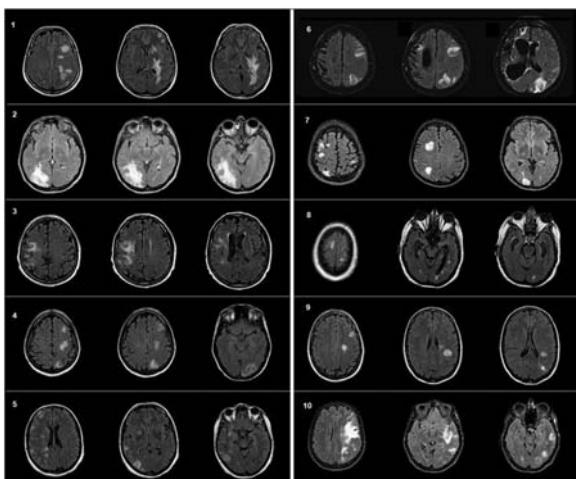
Brain magnetic resonance imaging, FLAIR sequence, axial slices: multifocal FLAIR hyperintense lesions are shown, ipsilateral to the hemisphere corresponding to endovascular treatment in each patient. Patient 1: aneurysm of the left anterior choroidal artery, patient 2: aneurysm of the right posterior communicating artery, patient 3: right middle cerebral artery ischaemic stroke, patient 4: aneurysm of the left intracranial carotid artery, patient 5: aneurysm of the right posterior communicating artery, patient 6: aneurysm of the left middle cerebral artery, patient 7: aneurysm of the right intracranial carotid artery, patient 8: aneurysm of the anterior communicating artery, patient 9: aneurysm of the left intracranial carotid artery, patient 10: aneurysm of the left posterior communicating artery.
